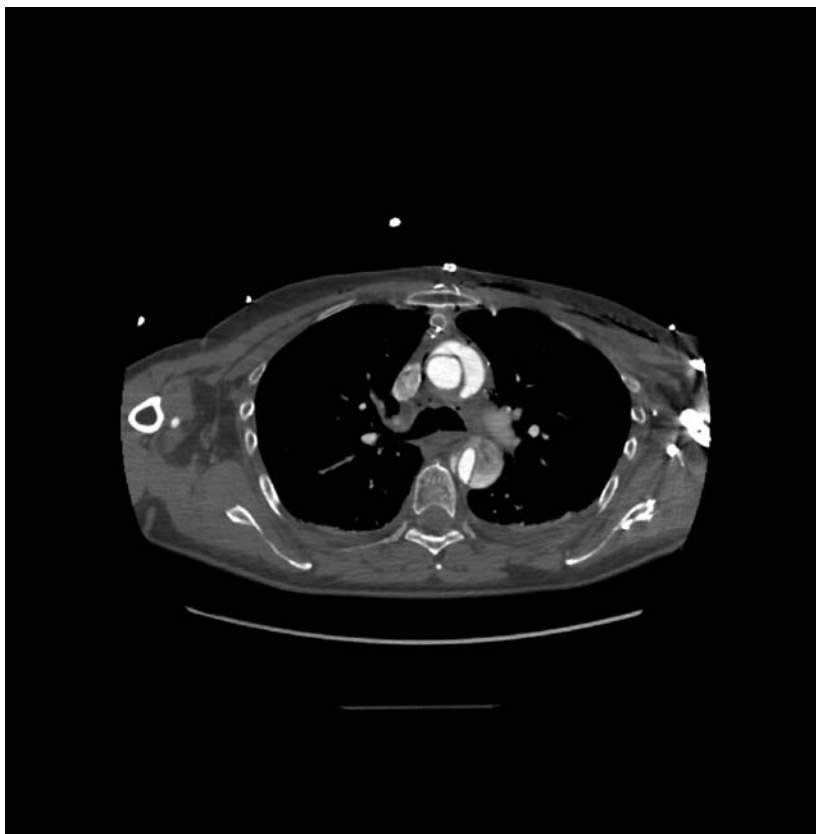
Angio-computed tomography scan on axial view showing an acute Type A aortic dissection with compression of the true lumen.
